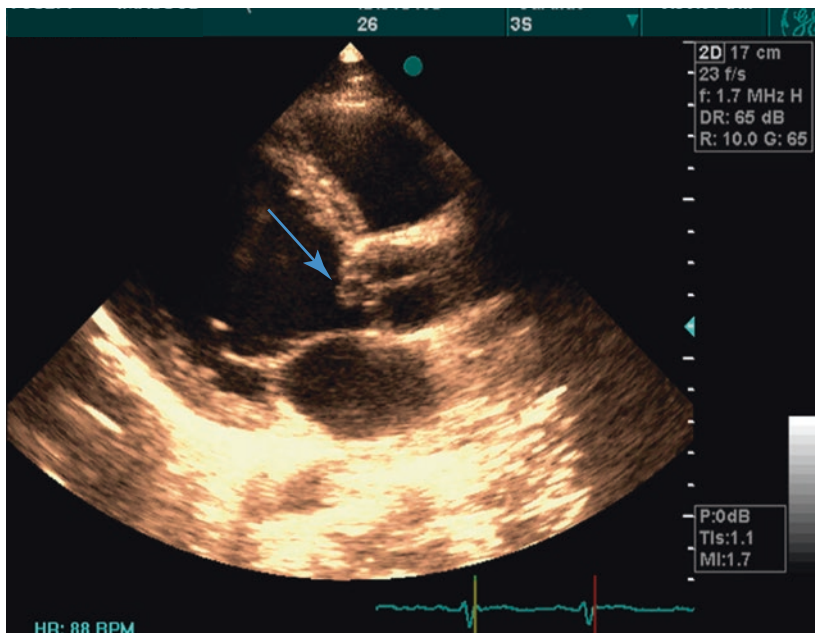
Parasternal long-axis view, severe LV enlargement, bicuspid AV, vegetation on AV (arrow)
